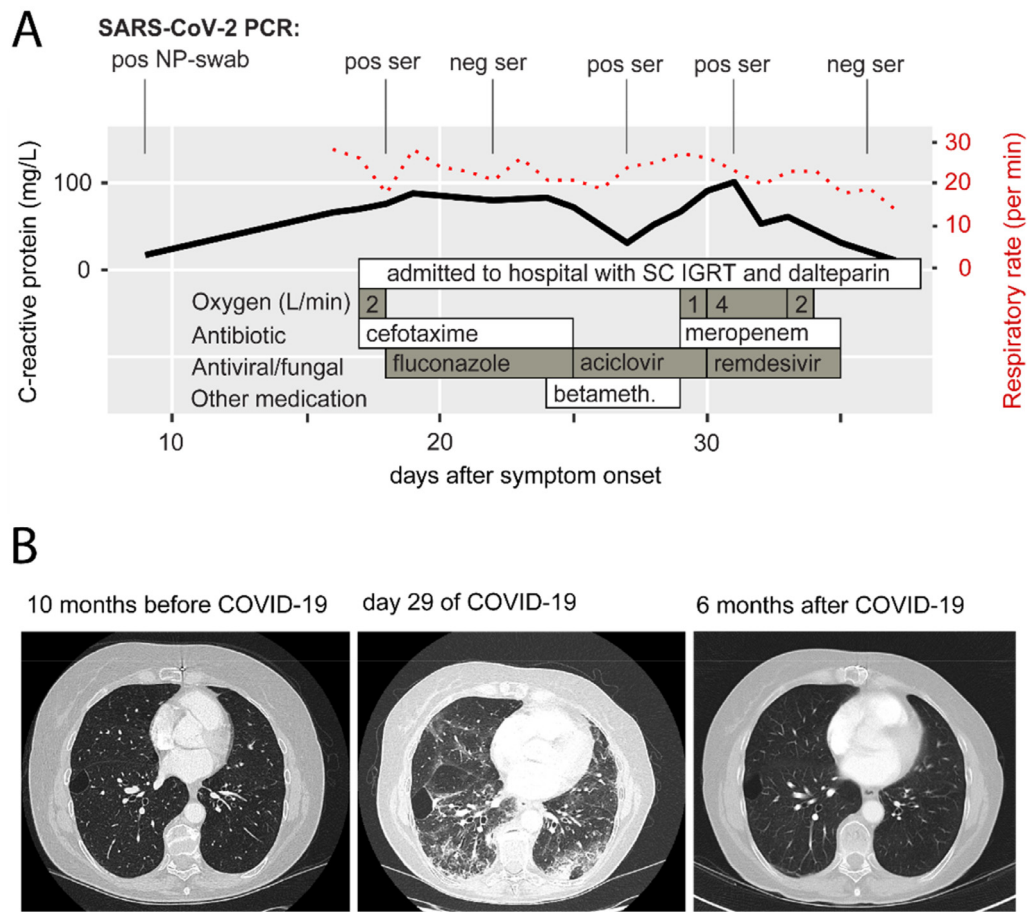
Disease course of COVID-19 in a patient with Good's syndrome. A Timeline representing C-reactive protein (solid black line) and respiratory rate (dotted red line) in relation to SARS-CoV-2 PCR results in nasopharyngeal (NP) swab and serum (ser) as well as significant treatments during hospitalization. IGRT, 6 g/wk; dalteparin, 5000 IU/d; cefotaxime, 1 g x 3/d; meropenem, 1 g x 3/d; fluconazole, 100 mg/d; aciclovir 200 mg x 5/d; remdesivir 200 mg day 1 then 100 mg/d; betamethasone, 2 mg/d. B Computed tomography of the lungs at peak of disease (center panel) showing ground-glass opacities in all lobes and bilateral basal confluent infiltrates, compared to time points several months before and after COVID-19. Pos, positive; neg, negative; SC, subcutaneous; IGRT, immunoglobulin replacement therapy; betameth., betamethasone.
